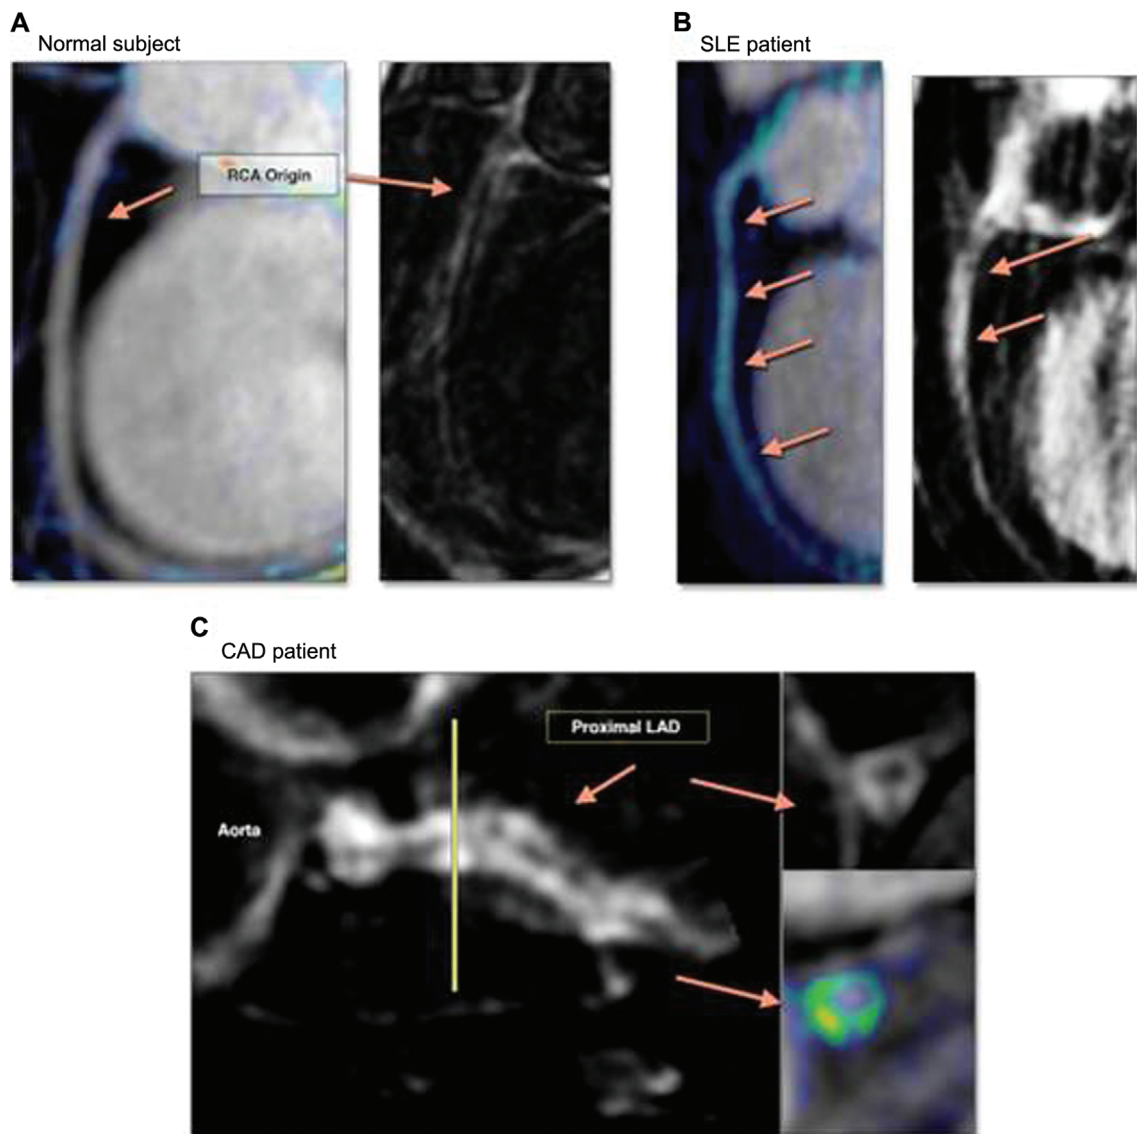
Representative Images of Clinical Findings with Contrast-Enhanced Magnetic Resonance Imaging. (A) Control subject (female, age 38 years) with mild right coronary artery (RCA) enhancement (*blue*). (B) A patient with systemic lupus erythematosus (SLE) (female, age 36 years), with generalized coronary enhancement over the projected long-axis view of the RCA. (C) A patient with coronary artery disease (CAD) (male, age 57 years), with patchy coronary enhancement within the area of soft plaque; short-axis view of the proximal part of the left coronary artery. LAD, left anterior descending artery. From Varma et al. [66], with permission from Elsevier.
